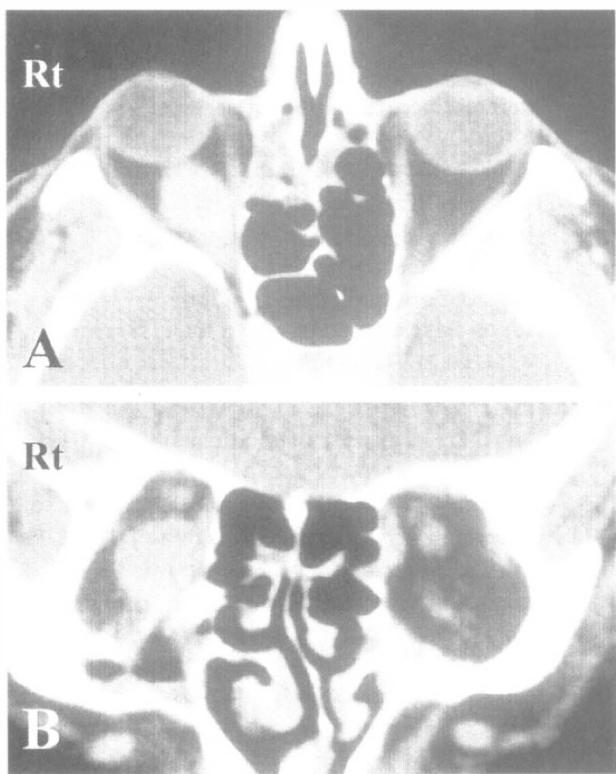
CT scans showing right proptosis due to massively enlarged inferior rectus muscle.
